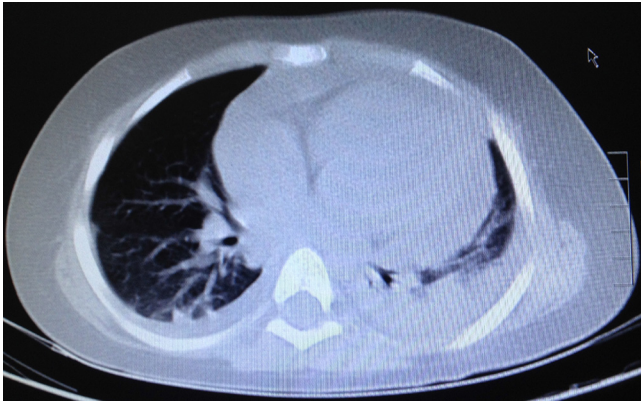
Computed tomography of the chest (CTC) showed left lung atelectasis, moderate pleural effusion and consolidation in the left upper lobe. CTC mediastinal window shows moderate pericardial effusion.
